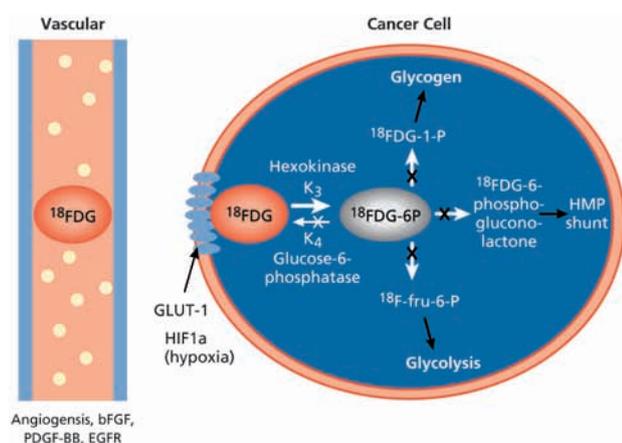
FDG uptake in a cancer cell.
